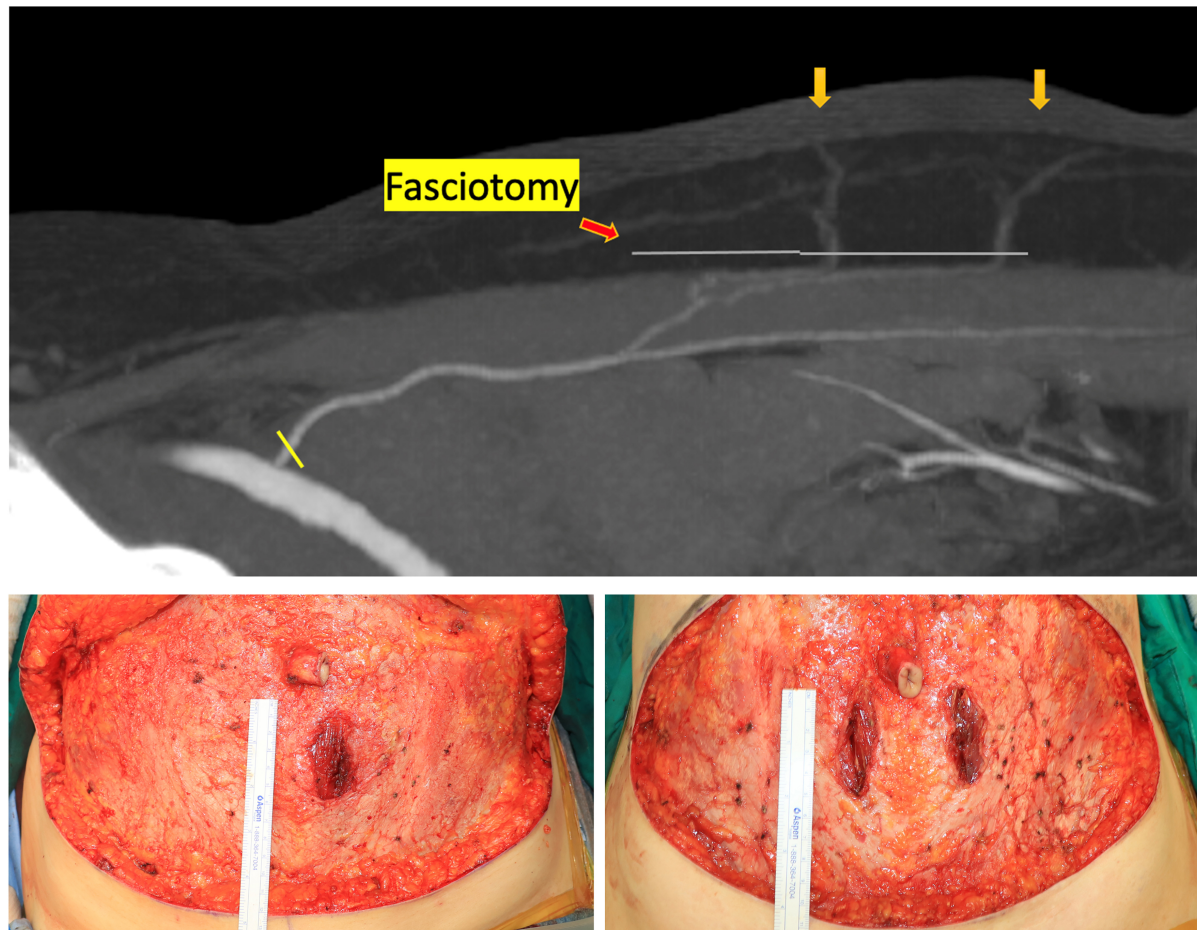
A fasciotomy is performed with only a minimal extension beyond the intramuscular course identified on CTA (above; the arrows indicate the length of the fasciotomy performed), followed by the result of the short-fasciotomy technique flap harvest (below). CTA: Computed tomography angiography.
